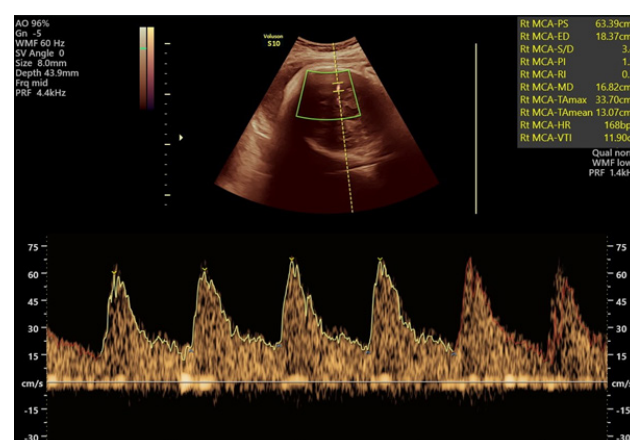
Middle cerebral artery Doppler with high systolic peak velocity normal indices, MCA PI = 1.34, MCA RI = 0.7
